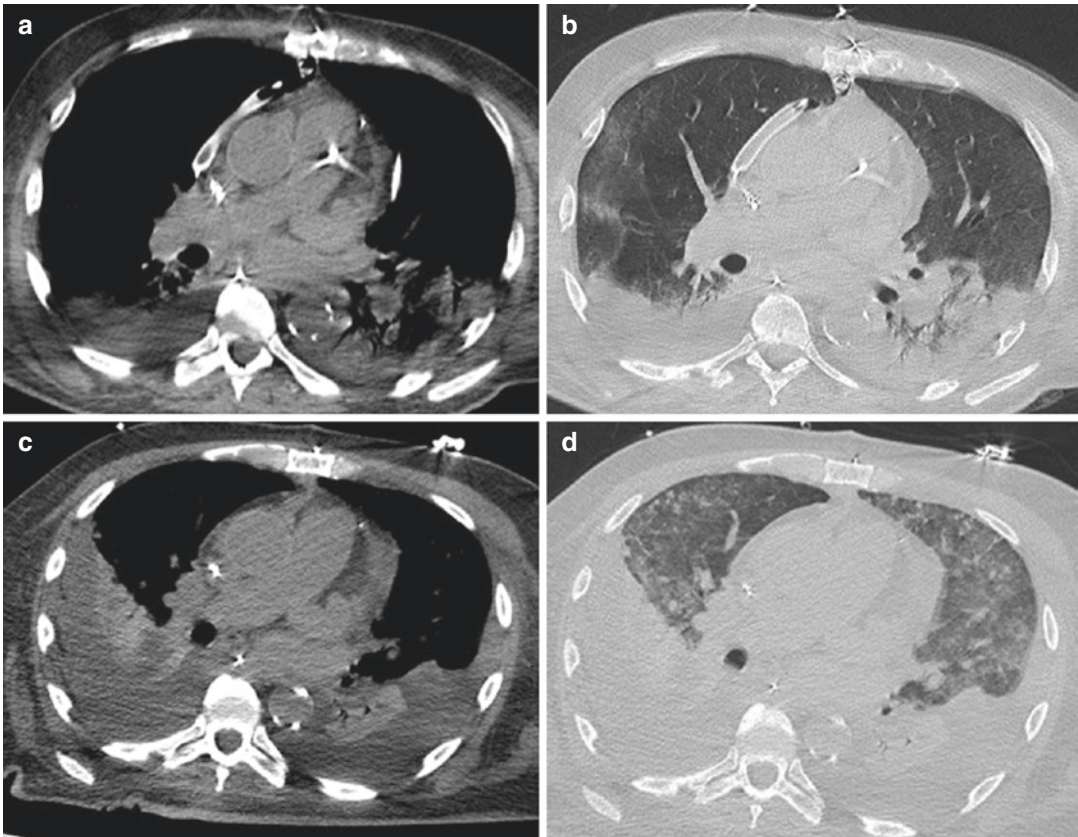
Complication of a pulmonary contusion. (a, b) Axial CT-scans show the parenchymal areas of consolidation immediately after trauma. Any kind of parenchymal
